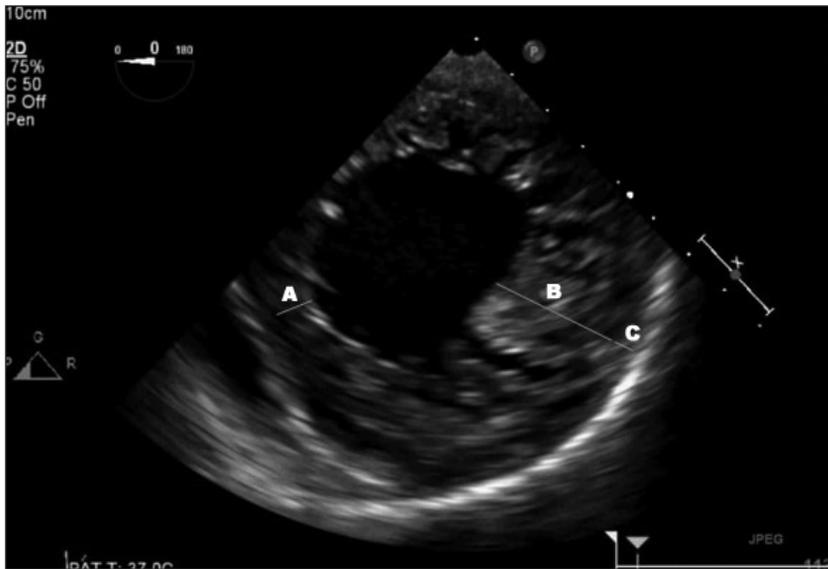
Transesophageal echocardiogram with wall thickness measurement showing A) normal nonaffected wall, B) noncompacted subendocardial layer, and C) thinner and compacted subepicardial layer. Ratio of B:A is greater than 2.
